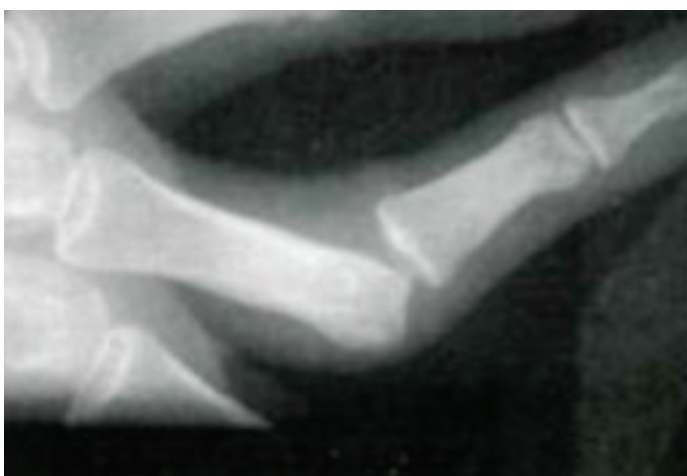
Radiograph of a lateral dislocation.
